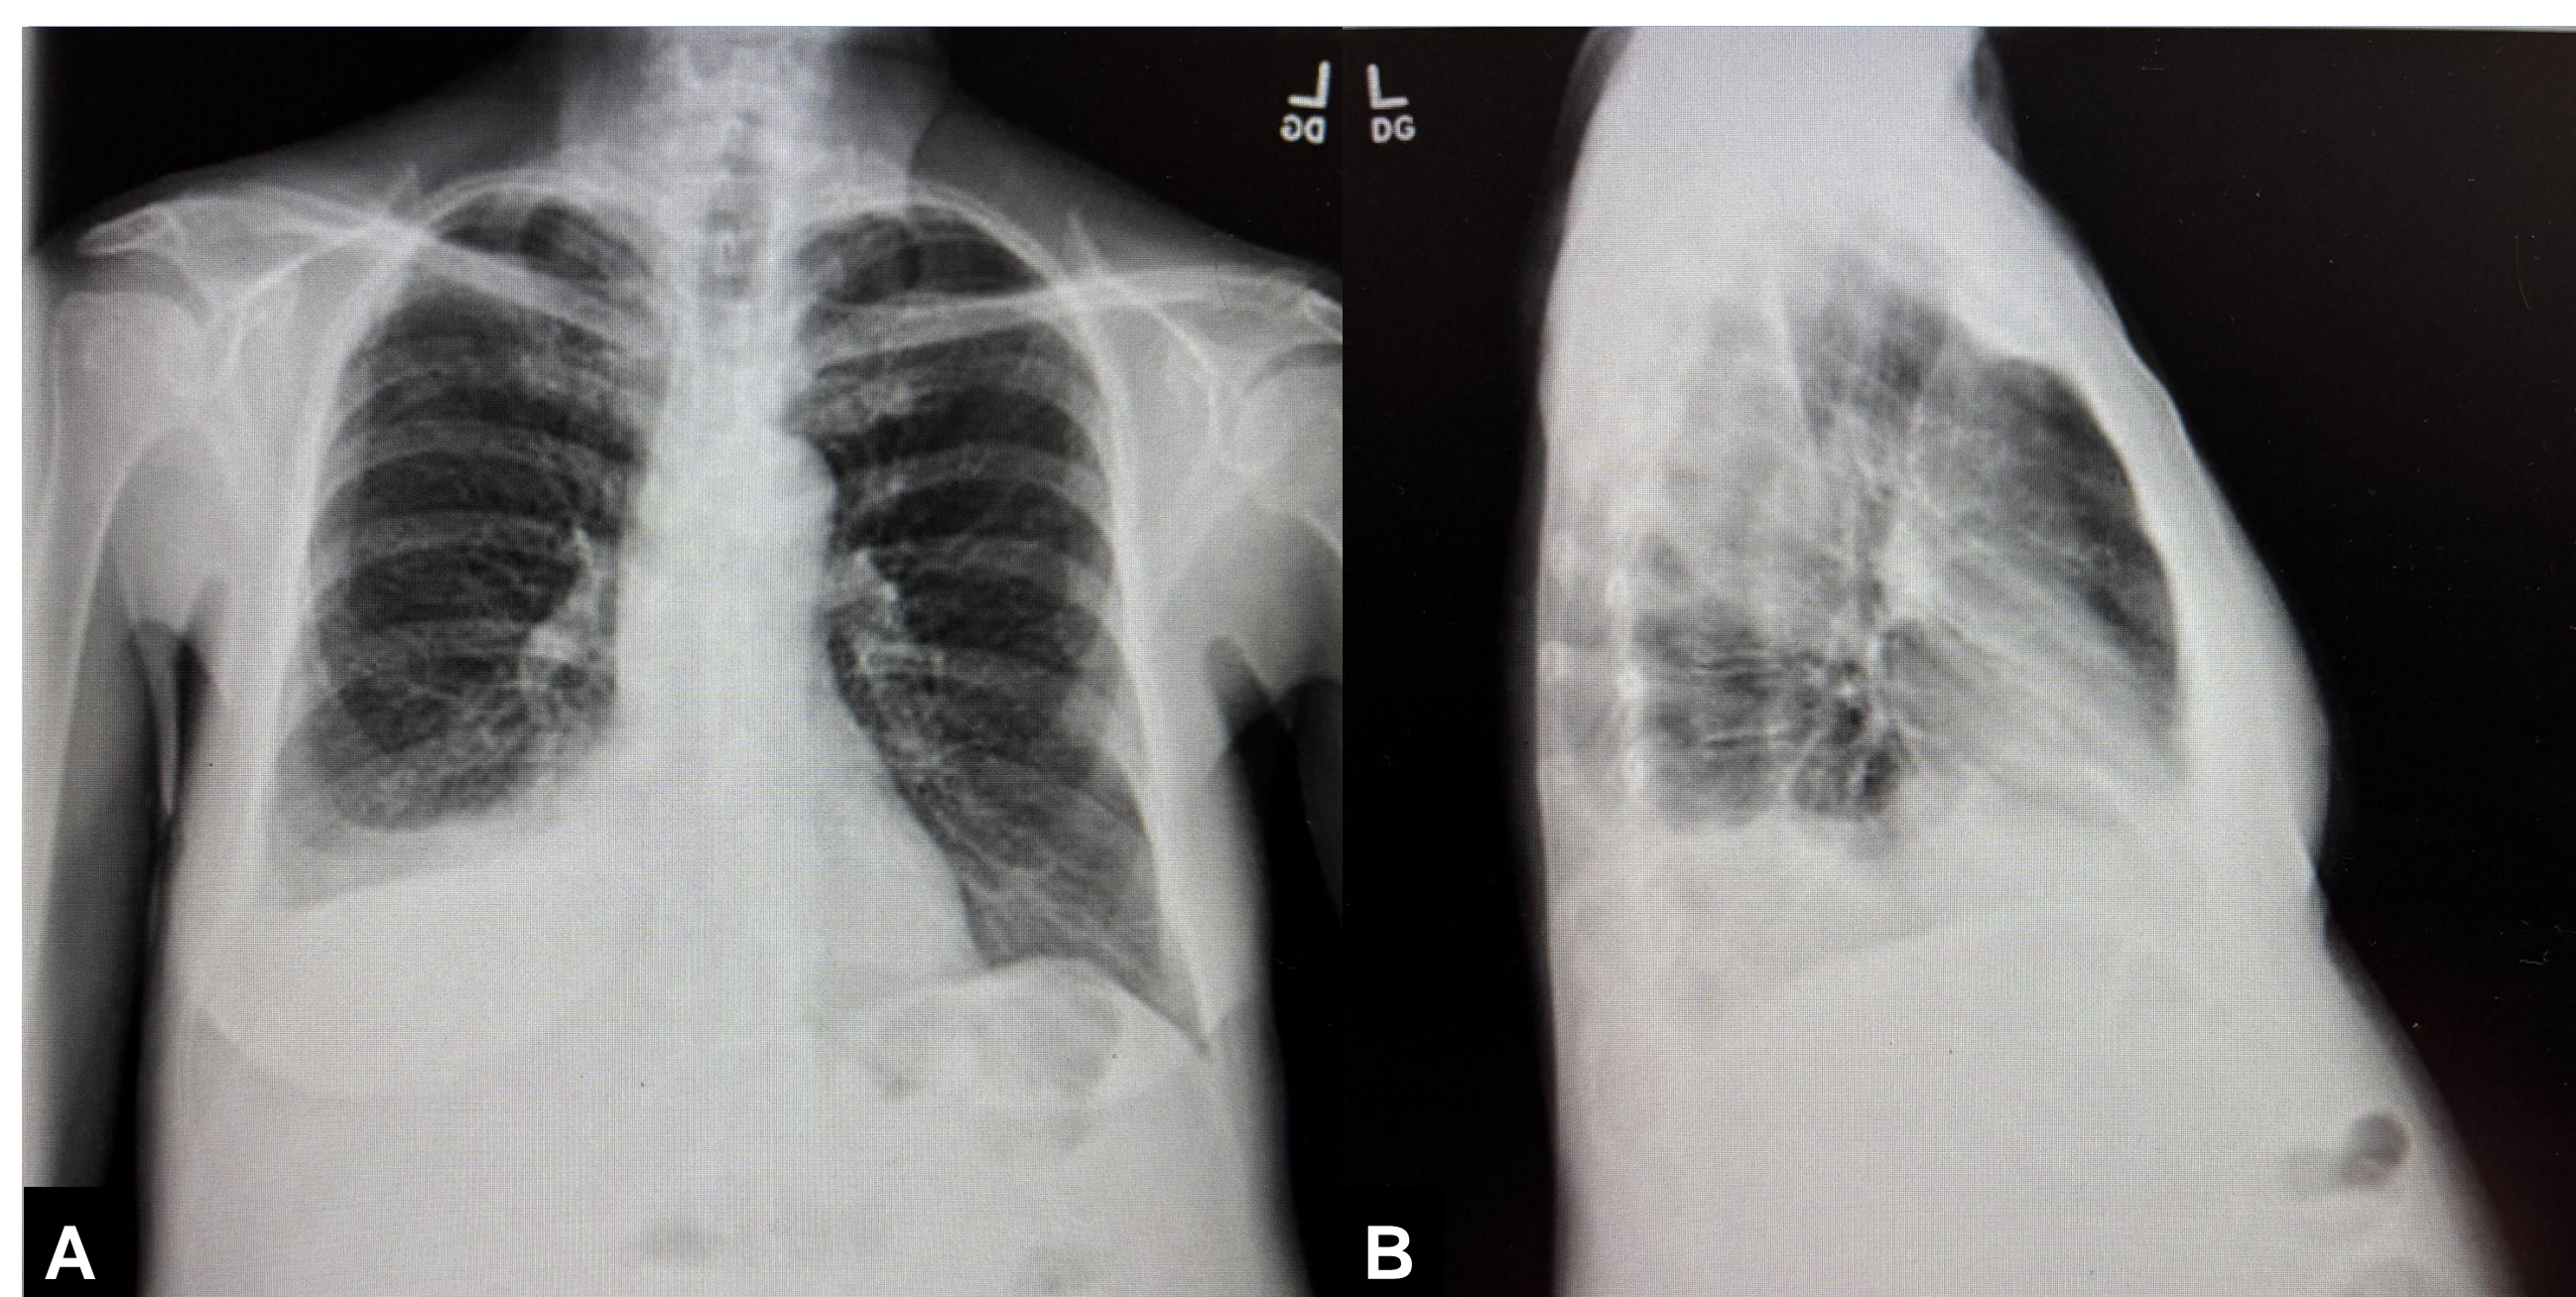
Chylous pleural effusions. (A) Posteroanterior view of chest X-ray showing moderate right pleural effusion. (B) Lateral view of the same chest X-ray showing moderate pleural effusion.
